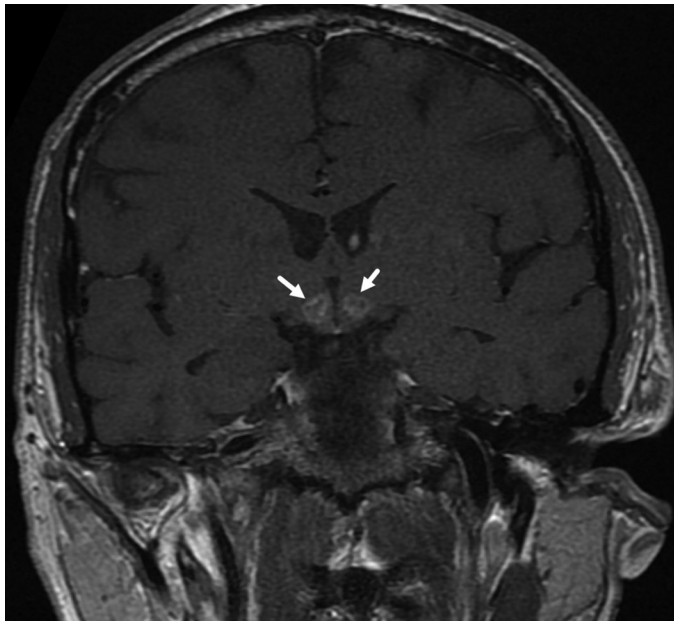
Contrast-enhanced T1-weighted image shows contrast enhancement in hypothalamus (white arrows)
